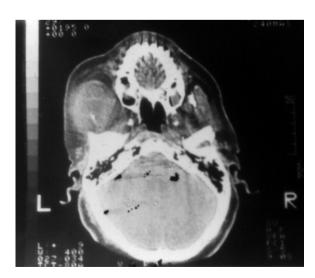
Axial CT image showing mass in the left infratemporal fossa.
